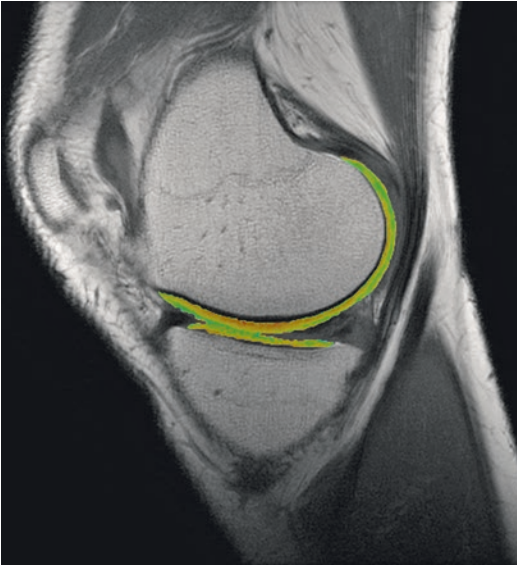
T2 mapping from a 3-Tesla MRI shows intact articular cartilage with no focal prolongation of relaxation times. (Reprinted from Noyes FR, Barber-Westin SD (2017) Meniscus tears: diagnosis, surgical techniques, and clinical outcomes. In: Noyes FR, Barber-Westin SD (eds) *Noyes' Knee Disorders: Surgery, Rehabilitation, Clinical Outcomes*. 2nd edn. Elsevier, Philadelphia, pp. 677–718)
